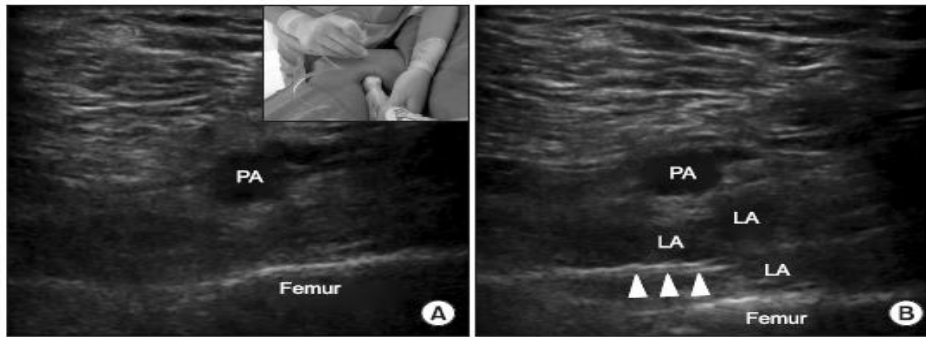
Ultrasound images demonstrating relevant sono-anatomy for the Infiltration between the Popliteal Artery and Capsule of the Knee (IPACK) before (A) and after (B) local anesthetic injection; PA: popliteal artery, LA: local anesthetic. Arrows indicate the distal end of the needle.
